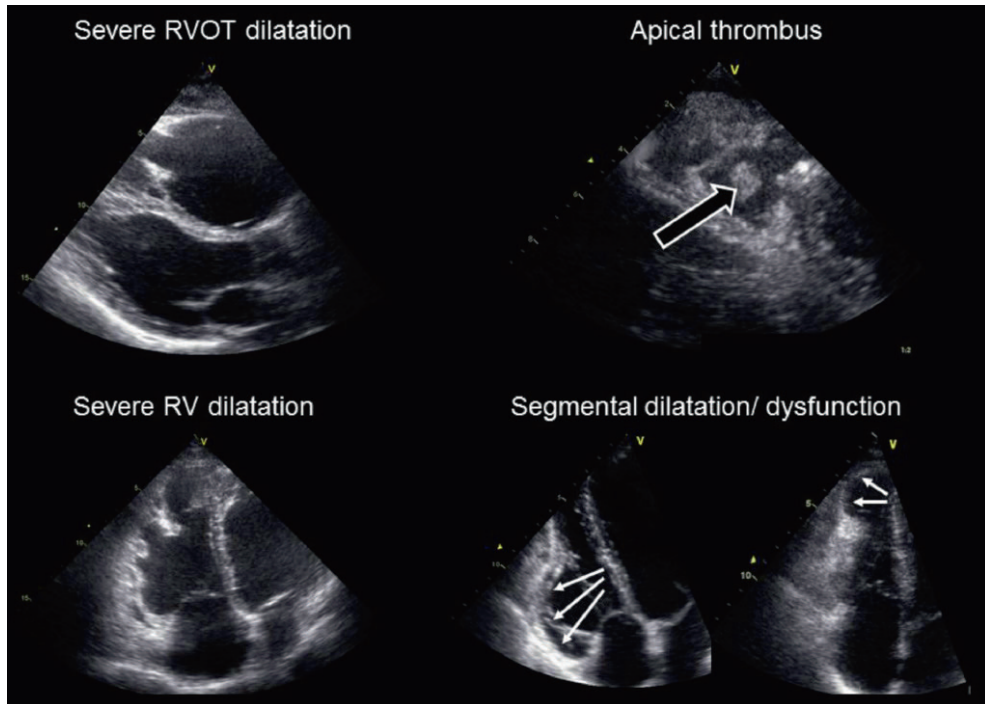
Conventional echocardiography in an arrhythmogenic right ventricular dysplasia/cardiomyopathy (ARVD/C) patient
